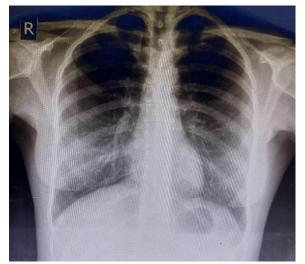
Follow-up chest X-ray shows no metastases.
